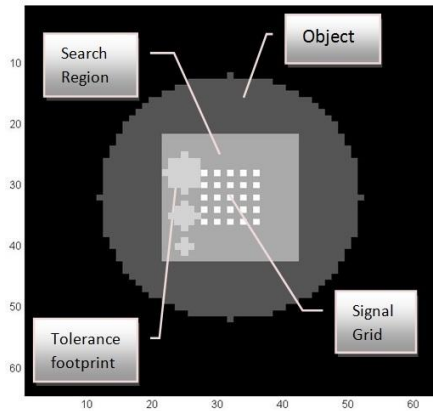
The SPECT Object. The tolerance footprints are superimposed on the object
